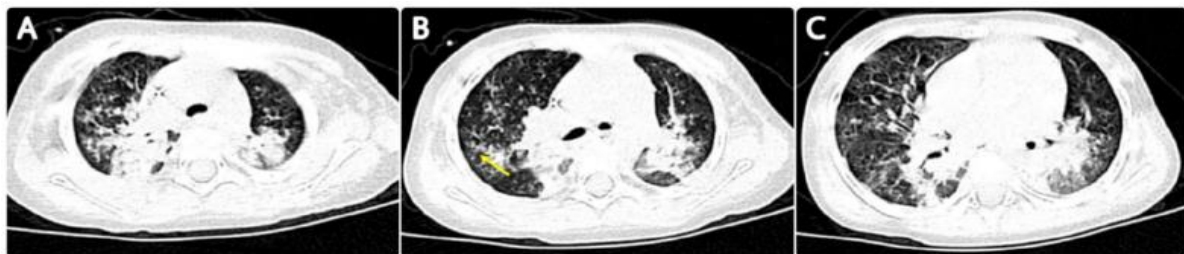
Chest CT on admission showing consolidation of both lungs with segmental atelectasis, centrilobular nodules, and a sign of tree-in-bud (yellow arrow)
